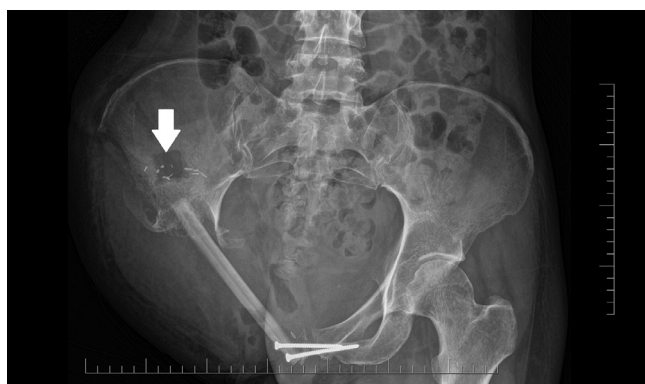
X-ray image of the bone fenestration performed in the area of the right iliac fossa (white arrow).
